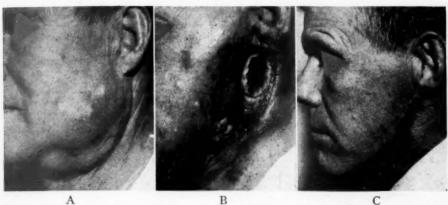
(A) Benign mixed tumor of the parotid gland of 28 years' duration. It had been excised twice and the patient had received one course of six roentgen treatments. (B) Lesion after chemosurgical excision which required twenty-four days. The final layer of fixed tissue had separated except for one area under the ear where a rather deep, unpredicted extension of the neoplasm had been followed out. The protruding tissue in the lower part of the wound is normal submaxillary salivary gland tissue. (C) Healed lesion showing absence of facial paralysis except for the unimportant mandibular branch. There has been no evidence of recurrence after more than three years.
